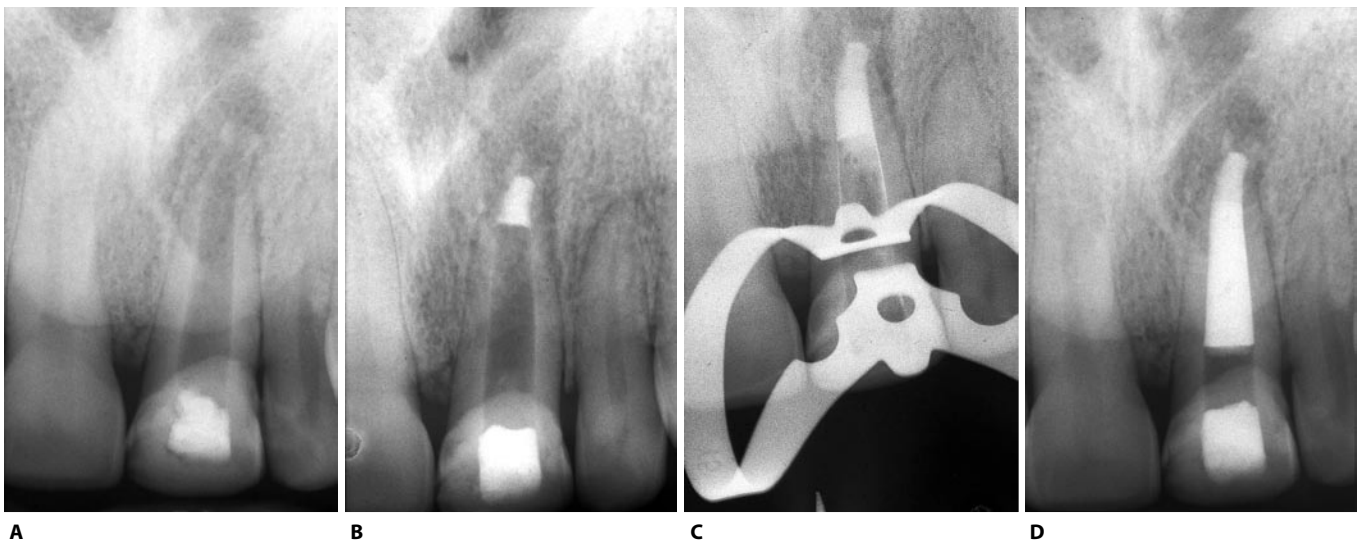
A. Preoperative radiograph of an upper right central incisor with an immature apex in an adult patient. B. The apical barrier of MTA. C. Deepest point of compaction of the thermoplastic gutta-percha. D. Postoperative radiograph.
